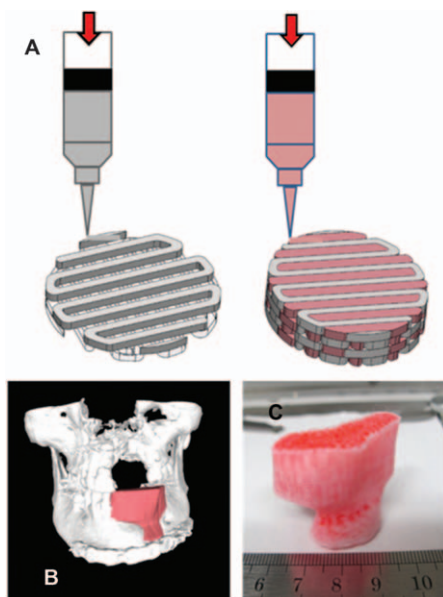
(A) Multi-material scaffold printing model. (B) CT scan of a craniofacial defect with filled defect. (C) Multi-material print of craniofacial defect scaffold. (B) and (C) reprinted from ref. 44 with permission from The Royal Society of Chemistry.
